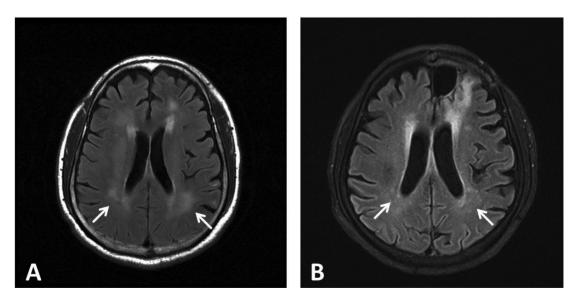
FLAIR Brain MRI of the patient on admission and two months after chemotherapy. (A) On admission, FLAIR showed multiple abnormal T2 hyperintense lesions over bilateral subcortical white matter, with some of the lesions showing mild diffusion restriction and contrast enhancement. (B) Two months after chemotherapy, the follow-up brain image showed left medial frontal post-operative change from the openbrain biopsy, and mild regression of bilateral subcortical white matter lesions as compared to (A).
